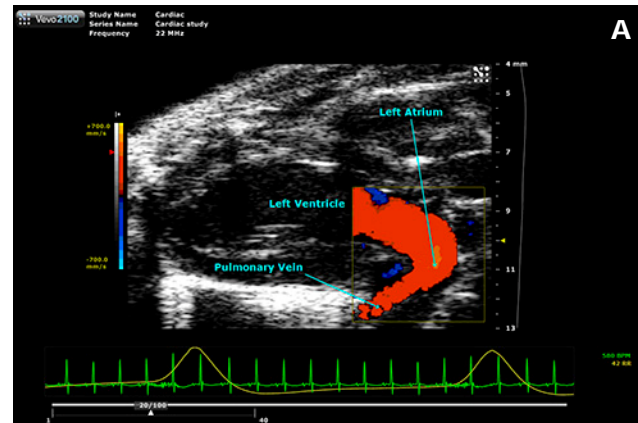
Color Doppler is used to identify the pulmonary veins (A), while Pulsed Wave Doppler is used to quantify the velocities of various peaks in the spectrum (B), including the systolic, diastolic and atrial peaks.
